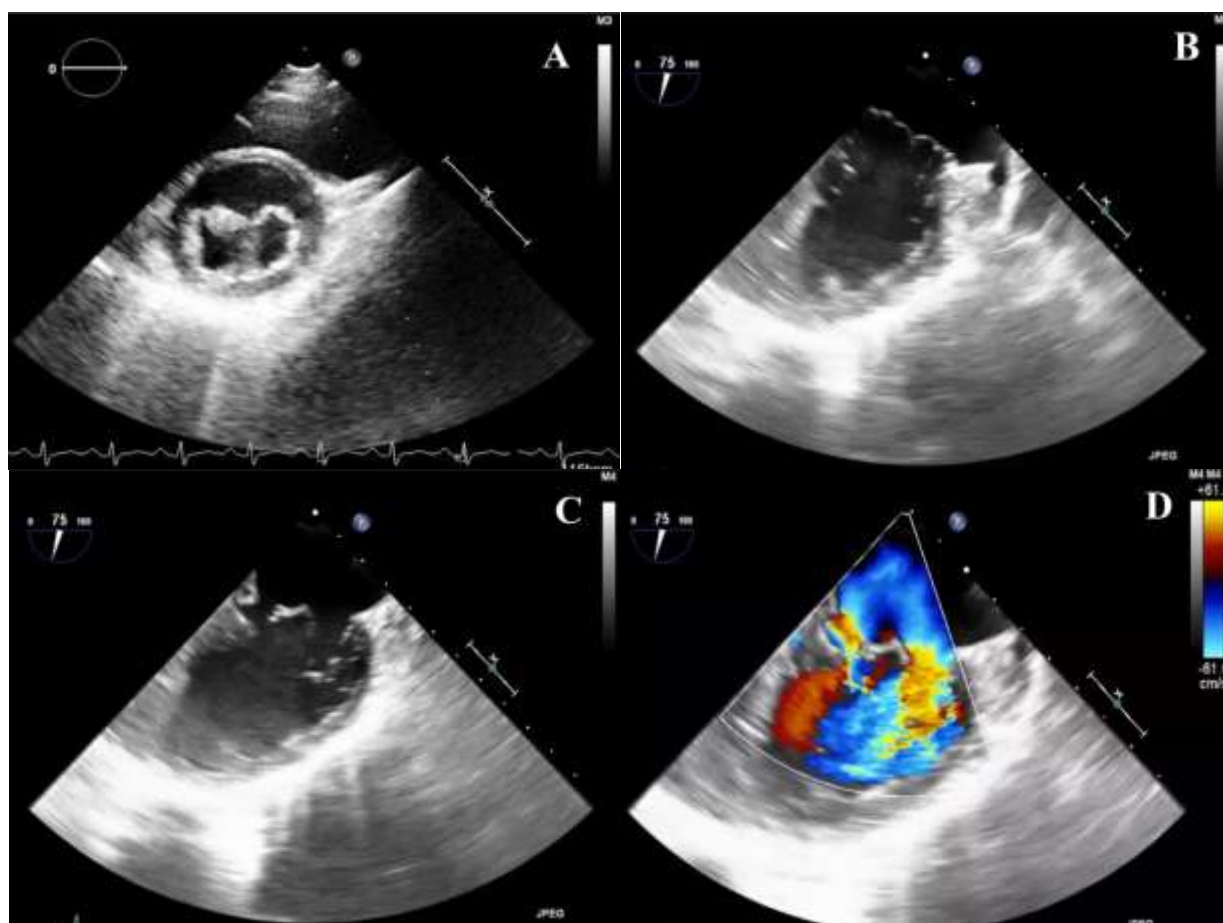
Transesophageal echocardiographic (TEE) images showing (A) double-orifice mitral valve (DOMV), two anatomical mitral valve (MV) leaflets in (B) systolic and (C) diastolic state, and (D) Doppler echocardiography of concomitant flows through two valves
